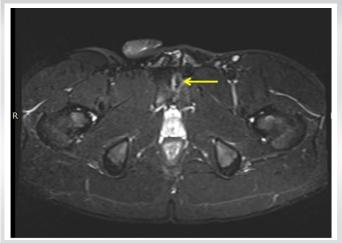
Magnetic resonance imaging in axial STIR view shows a hyperintensity signal zone in the left pubic branch suggesting pre-pubic aponeurotic complex injury.
